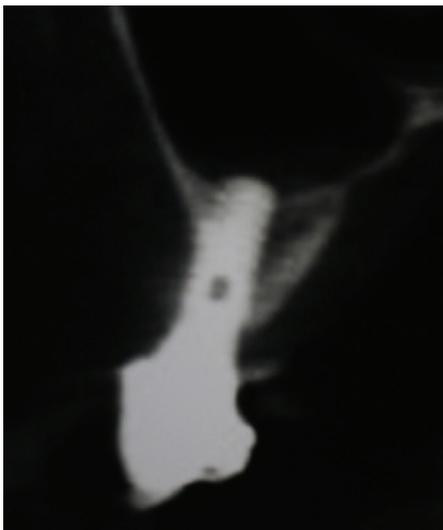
Initial radiograph.
